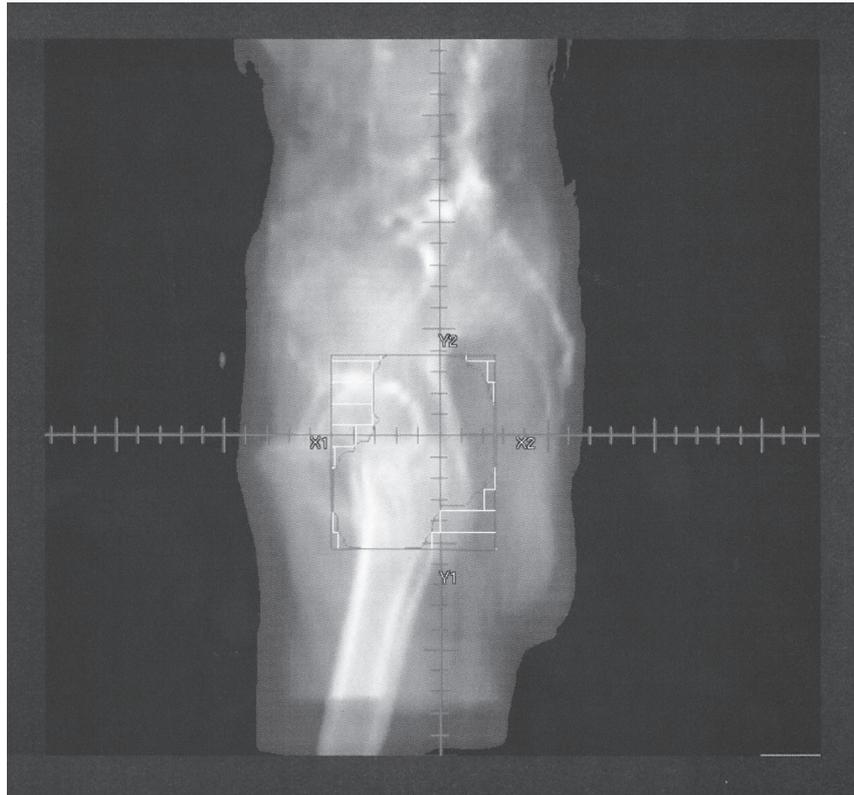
Digitally reconstructed radiographic image of the tumor and parametrium as the irradiation field in small field.
